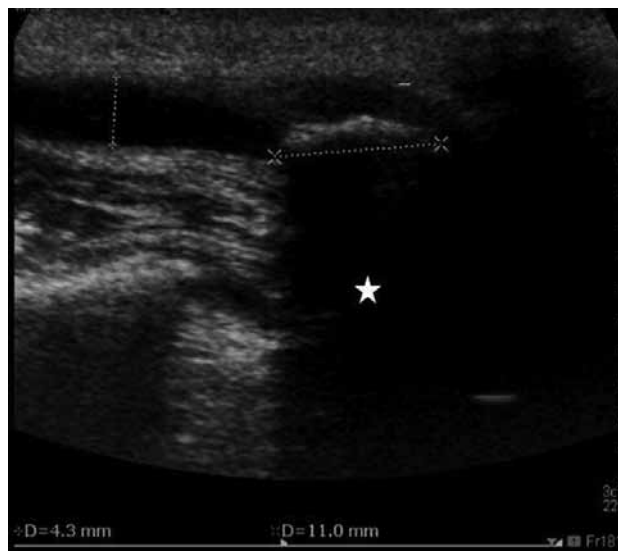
Ultrasound image of a submandibular duct stone. Note the dilated duct (vertical line: 4.3 mm), the stone (horizontal line: 11 mm) and the retro acoustic shadow to the stone (white star)
